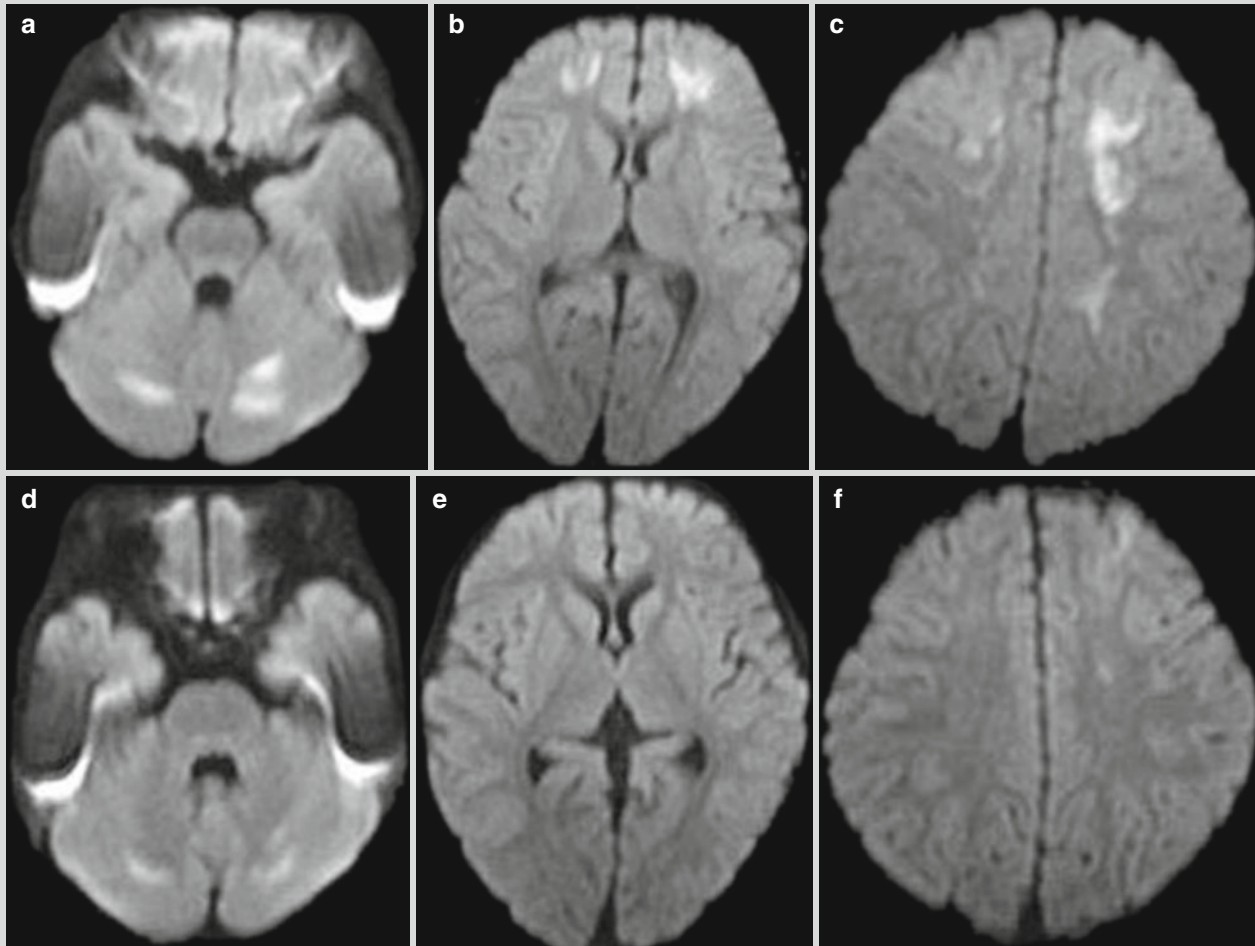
Rotavirus encephalitis. (a–c) At day 3 after hospitalization, DWI demonstrates obvious high signals at the left cerebral hemisphere, the white matter of bilateral frontal lobes, and dentate nucleus.
